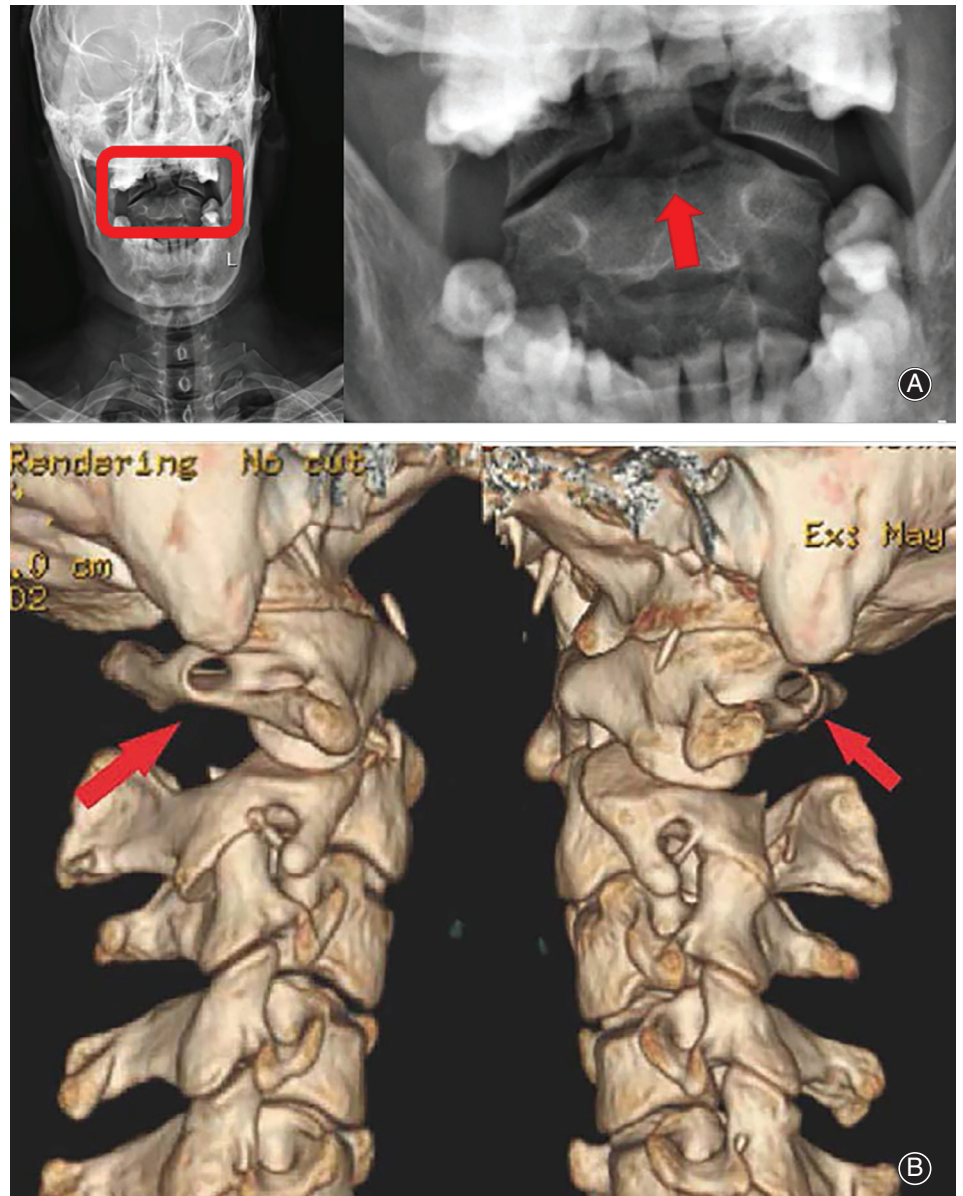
(A) X-ray showed fractures of epistropheus (arrows). (B) 3D-CT also showed a dormant variation of bilateral AF (arrows).
